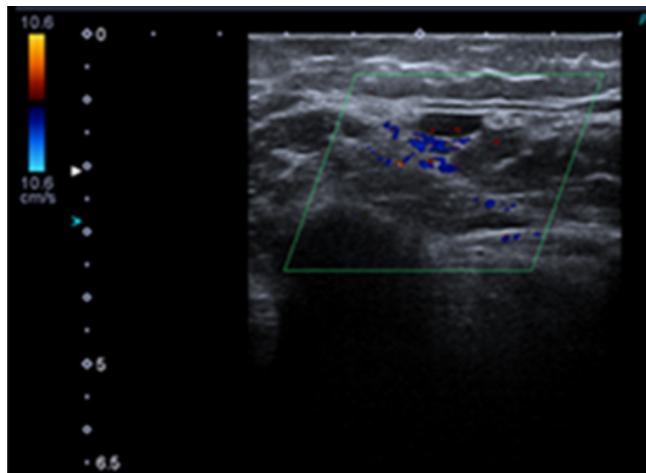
Echogenic material inside the cephalic vein of the forearm without Doppler flow inside.
